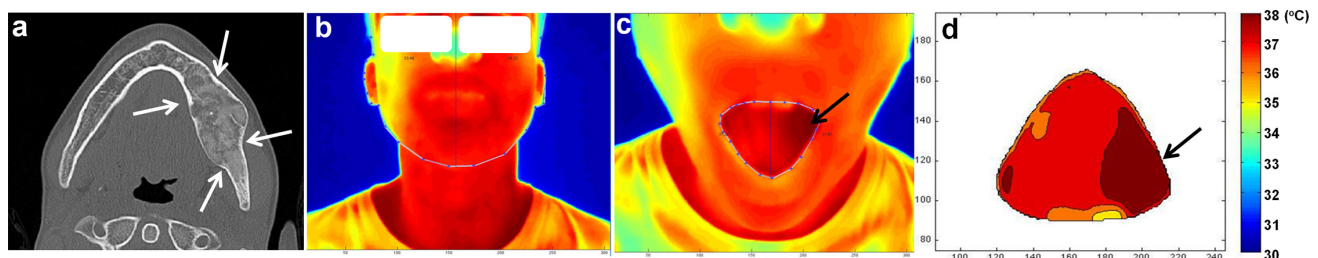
CT vs IRT images obtained in a 15-year-old male patient with fibrous dysplasia on the left side and with visible deformity of the mandible in axial CT image of affected jaw (a) vs TIs in frontal closed-mouth (b) and in open-mouth projections (c). Note: in CT image (a) expansion on the left side of the mandible with ground-glass opacities (marked by arrows) is evident. Accordingly, in the TIs there are evident asymmetrical temperature changes on the left side of the face (b) and of the mouth cavity before and after segmentation (c, d, respectively). Segmentation highlighted the lesion in dark (marked by arrow). Other notations are the same as in Figure 2. IRT, infrared thermography.
